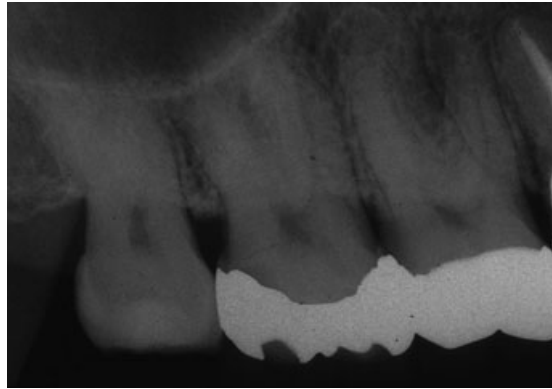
Pre-operative radiograph of the third molar.
